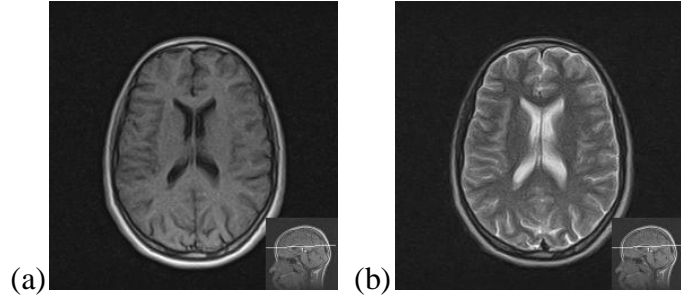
Original raw MRI data from Pioneer Diagnostic Center. a) T1-w axial scan image, b) T2-w axial scan image.
